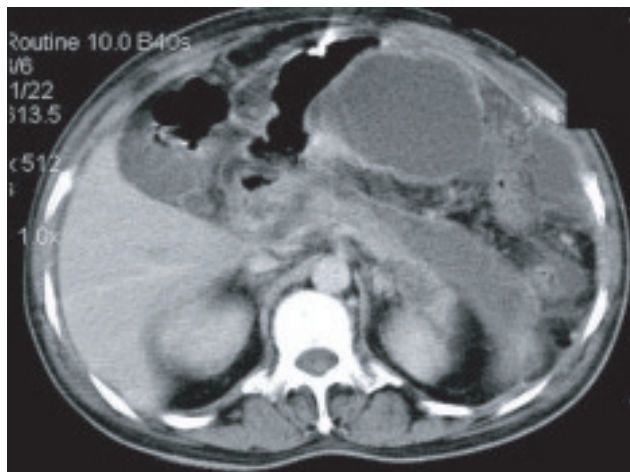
CT showed acute necrotizing pancreatitis with peripancreatic collections
